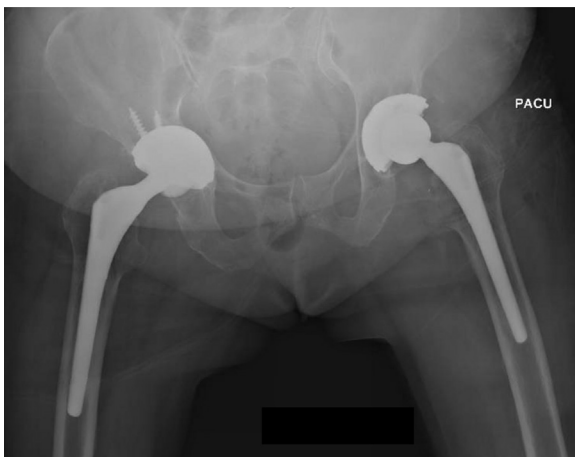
Immediate postoperative anteroposterior radiograph of the pelvis demonstrating removal of hardware with retention of original osteointegrated components.
